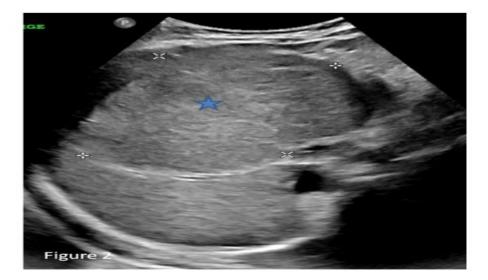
Ultrasound liver showing well marginated isoechoic nodule (star) in right lobe of liver.
